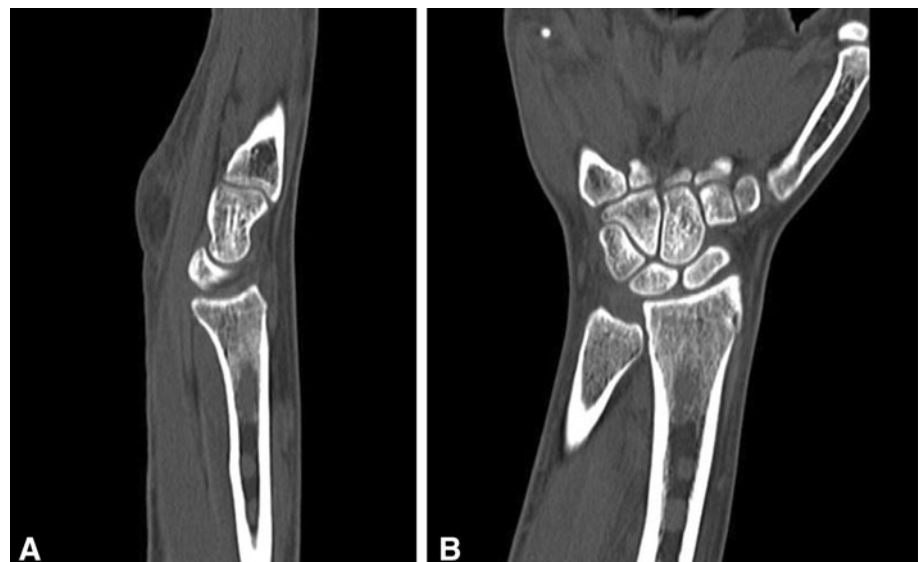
B (A) Sagittal and (B) coronal reconstructions of a CT scan of the wrist show multiple permeative lesions in the distal radius that are not as well-defined as those seen on MRI.
